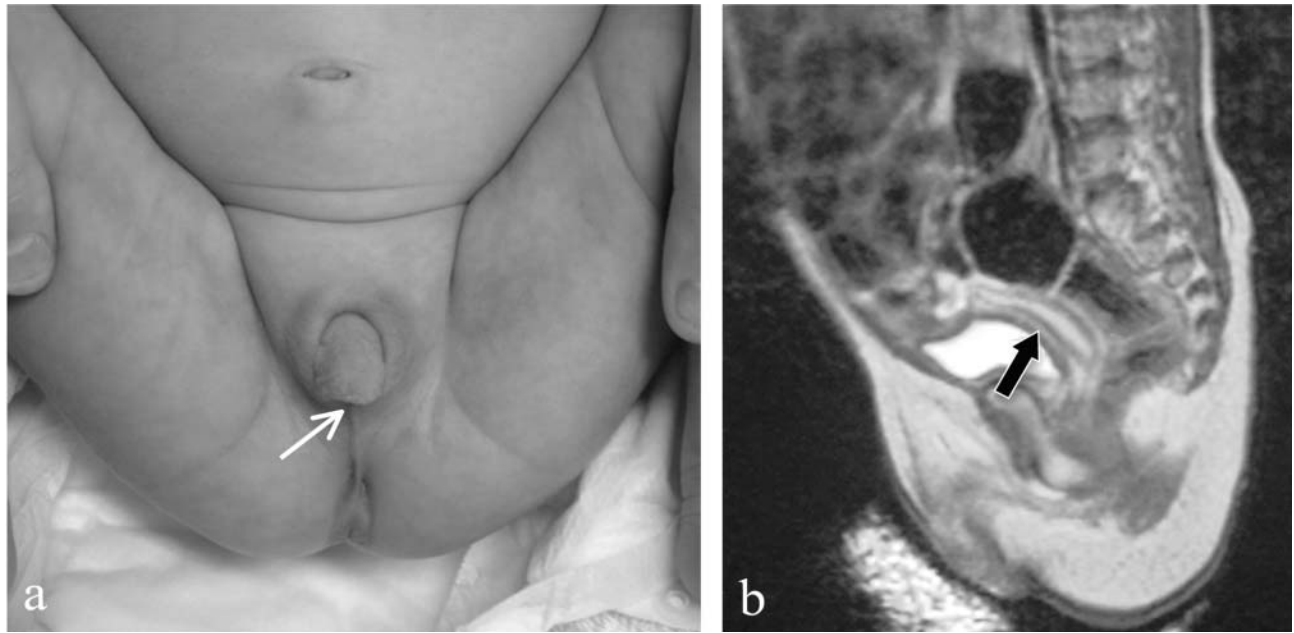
a) External genitalia of the neonate. The neonate exhibited complete masculinization of the external genitalia with the external urethral meatus opening at the apex of the penis and complete labial fusion (Prader type V). (arrow indicates the external urethral meatus). b) MRI findings revealing a small uterus; the uterine corpus and the cervix are not distinguishable, and the vagina is closed just beneath the labia (arrow indicates the uterus).
